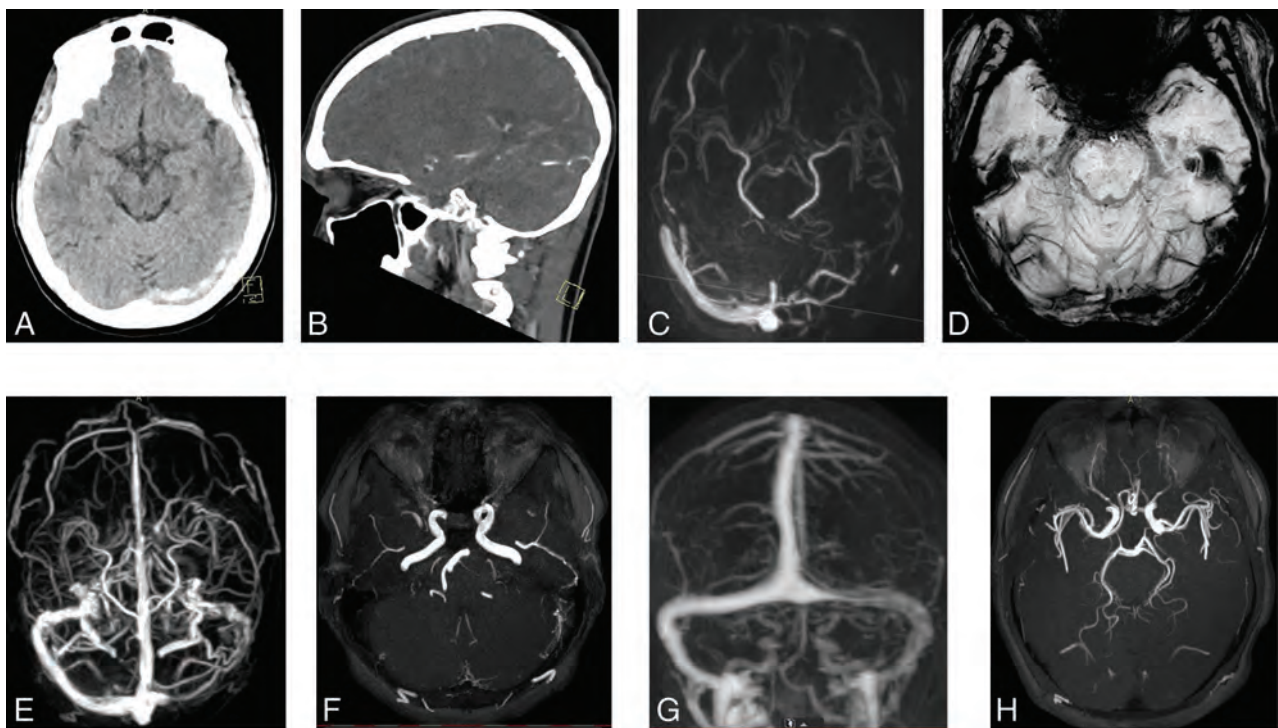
A 19-year-old man with a history of alpha-thalassemia type 2, a carrier of sickle cell disease and ulcerative colitis, underwent imaging because of relapsing headaches. Noncontrast CT shows hyperdensity in the left transverse sinus (A). Sinus thrombosis is confirmed on CT venography (B). One week later, phase-contrast MR venography shows absent flow in the left transverse and sigmoid sinuses without signs of arterIALIZATION of the sinuses (C). Persistent thrombosis of the sinus is depicted on SWI (D). Six months later, the patient presented with a pulsatile tinnitus; repeat MR imaging shows partial reopening of the sigmoid sinus (E) but also reveals a dAVF at the left sigmoid sinus (F). One year later, dynamic contrast-enhanced MRA (G) shows restoration of sinus flow and spontaneous obliteration of the dAVF (H).
